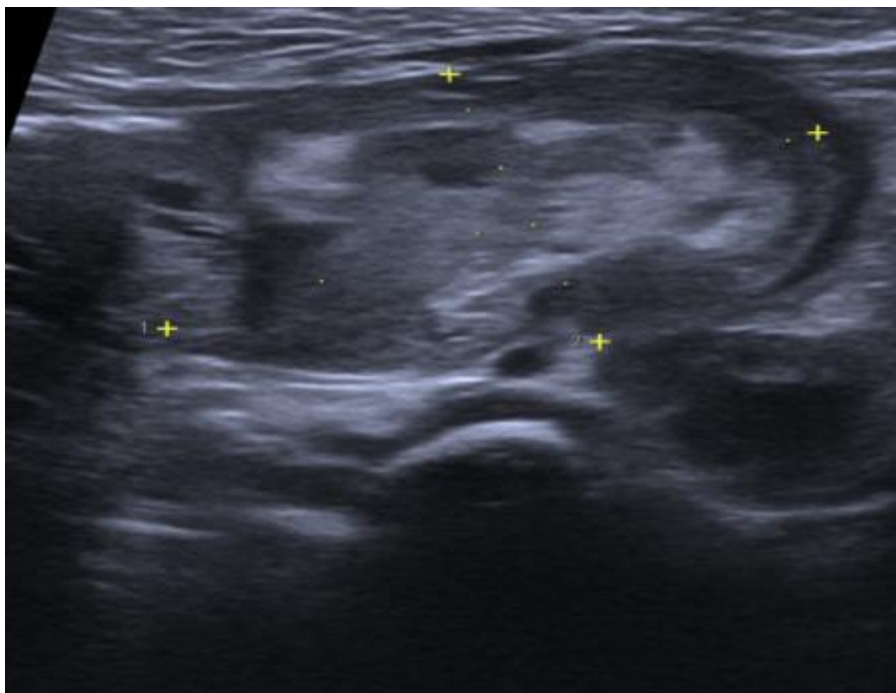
Ultrasound image of an gregolelic intussusception, with D1 measuring 41,5mm and D2 measuring 23 mm
